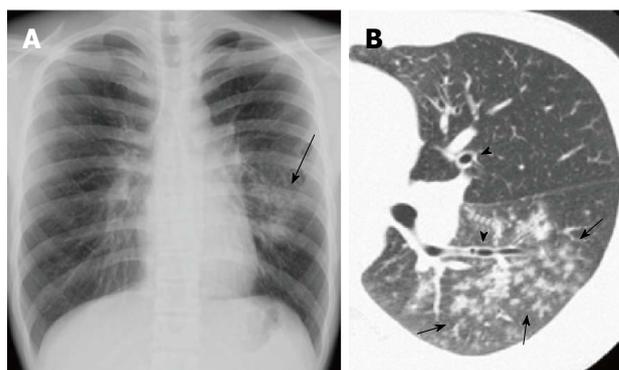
Mycoplasma pneumoniae* pneumonia showing bronchopneumonia in a man in his 10s. A: Chest radiograph shows reticulonodular opacities and focal consolidation in the left middle to lower lung field (arrow). The left pulmonary hilum appears enlarged; B: Thin-section computed tomography demonstrates fluffy centrilobular nodules with surrounding ground-glass opacity in the left lower lobe (arrows). Note that central bronchial wall is thickened (arrow heads).
